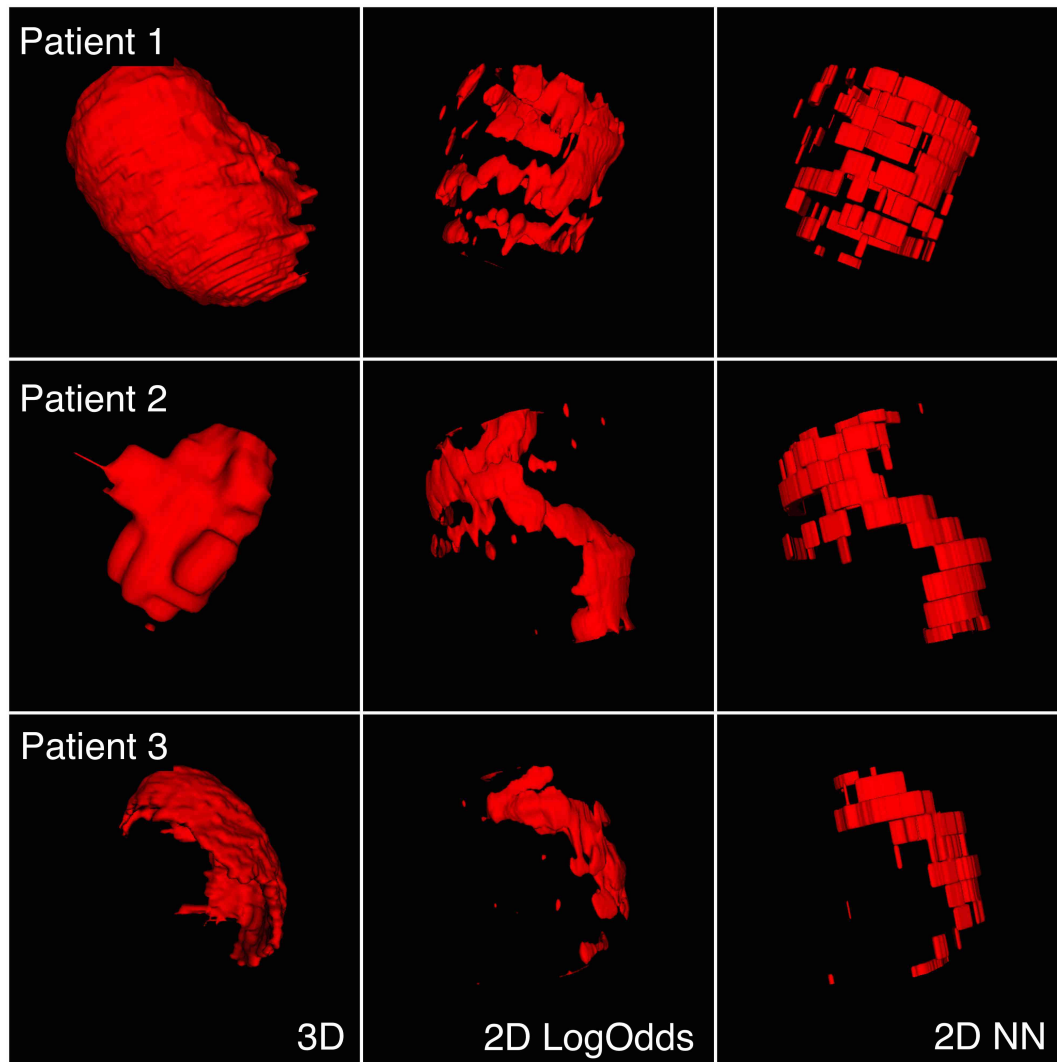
Scar geometries of two different patients (two rows) using 3D LGE-MRI (left column) and 2D LGE-MRI (other two columns) are seen. The 2D scar segmentations are reconstructed using two different reconstruction methods, namely, cubic LogOdds (middle column), and standard nearest neighbor (right column).
